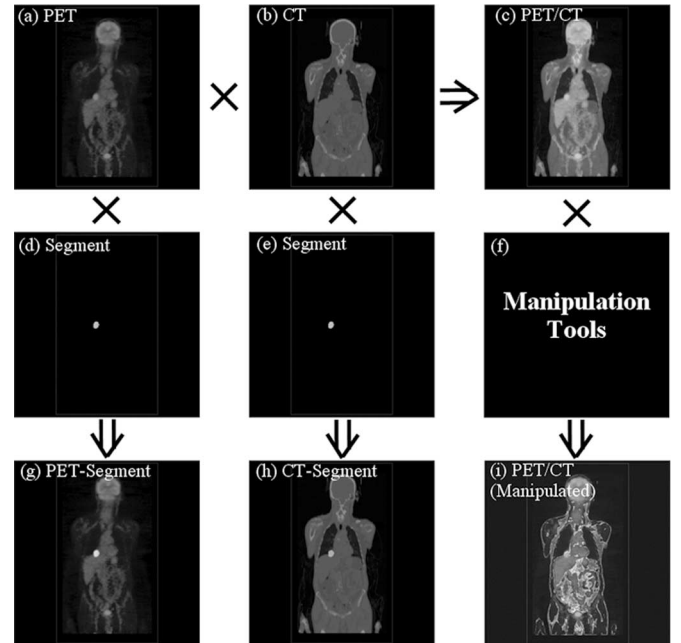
Overview of the main features in the proposed interactive multi-volume visualization. Individual volumes can be rendered (a) and (b) or can be combined with another volume, such as PET/CT (c). Combination of volumes and the ability to interchange the volumes in real time allows the segmented VOI of a tumor (d) and (e) to be fused and visualized with PET (g) and CT (h). The VOI is displayed using the white LUT for presentation purpose. Volume manipulations can be applied to individual volumes with the volumes being fused and the volume rendered in real time as shown in (i) where the CT has been thresholded to reveal the lung boundary surrounding the tumor.
